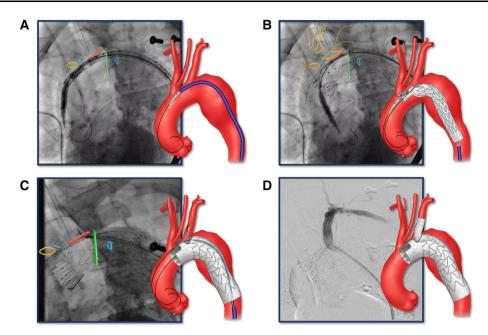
Bilateral percutaneous femoral approach using pre-closure technique was established using duplex ultrasound guidance. Systemic heparinization was performed to achieve an activated clotting time (ACT) > 250 s. A 0.035-inch double curve Lunderquist wire (Cook Medical, Bloomington, Indiana, USA) was positioned in the proximal ascending aorta. Angiography was performed to identify the supra-aortic trunks and calibrate the on-lay fusion. The arch branch stent graft was flushed with carbon dioxide and subsequently with heparinized saline [19]. The stent graft was introduced over the Lunderquist wire and advanced into position. Systolic blood pressure was decreased to approximately 90 mmHg prior to device deployment. A Stent graft was introduced over Lunderquist wire and advanced into position using radiopaque markers and on-lay fusion. B Arch branch stent graft was deployed. C A second Lunderquist wire was advanced via the pre-loaded catheter through the retrograde LSA branch up to the ascending aorta. The aortic stent graft delivery system and the main aortic Lunderquist wire were removed and a 22
